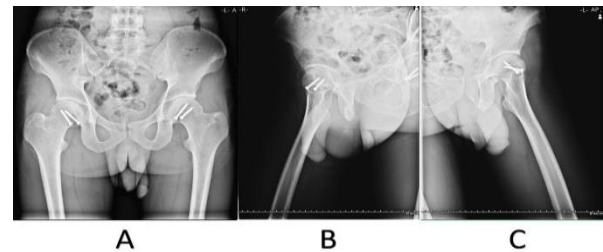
Post-operative radiograph (18-month follow-up): Complete union of bilateral femoral head fractures in anteroposterior (AP) view of the pelvis with no signs of avascular necrosis (AVN) (A). Lateral view of the right hip (B), Lateral view of the left hip (C)
